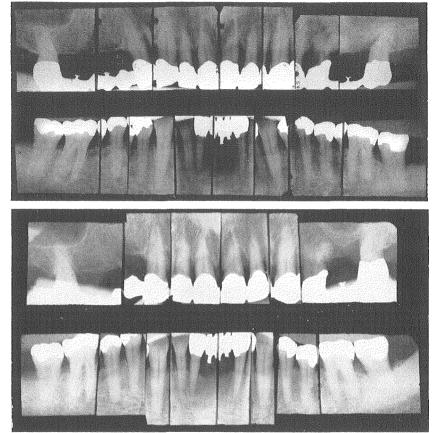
Roentgenograms taken 42 months after articulated restoration.
